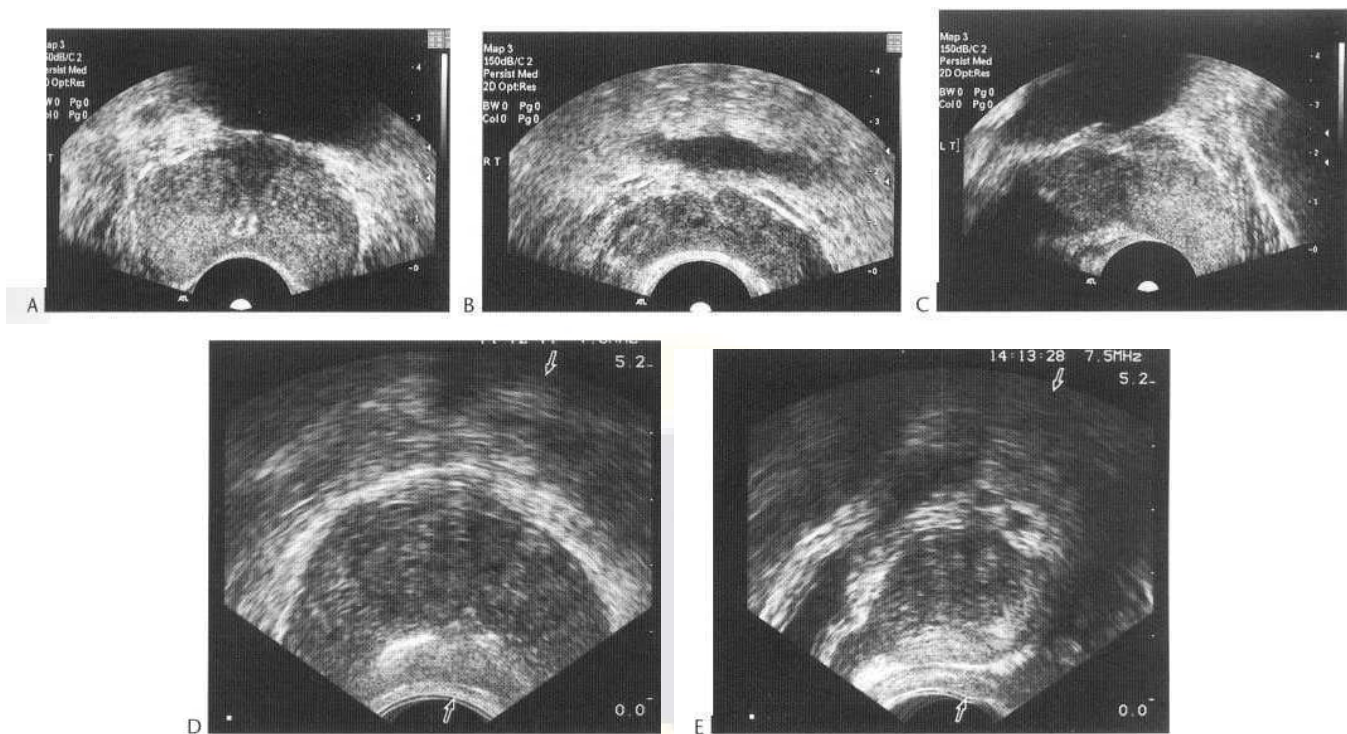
Transrectal ultrasound of the prostate. (A-C) Young adult prostate. (A) Transverse section. There is a little calcification appearing as speckled echogenicity in the periurethral area, presumed to be related to previous prostatitis and urethritis. The prostate at this age shows poor zonal anatomy. (B) Transverse view of the normal paired echo-poor seminal vesicles. (C) Longitudinal view showing the subjacent puborectalis sling as a laminated, relatively echo-poor structure. (D, E) Transverse and longitudinal views of the prostate around middle to old age. The zonal anatomy is clearly seen with a relatively hyperechoic peripheral gland compared to the hypoechoic central gland.
